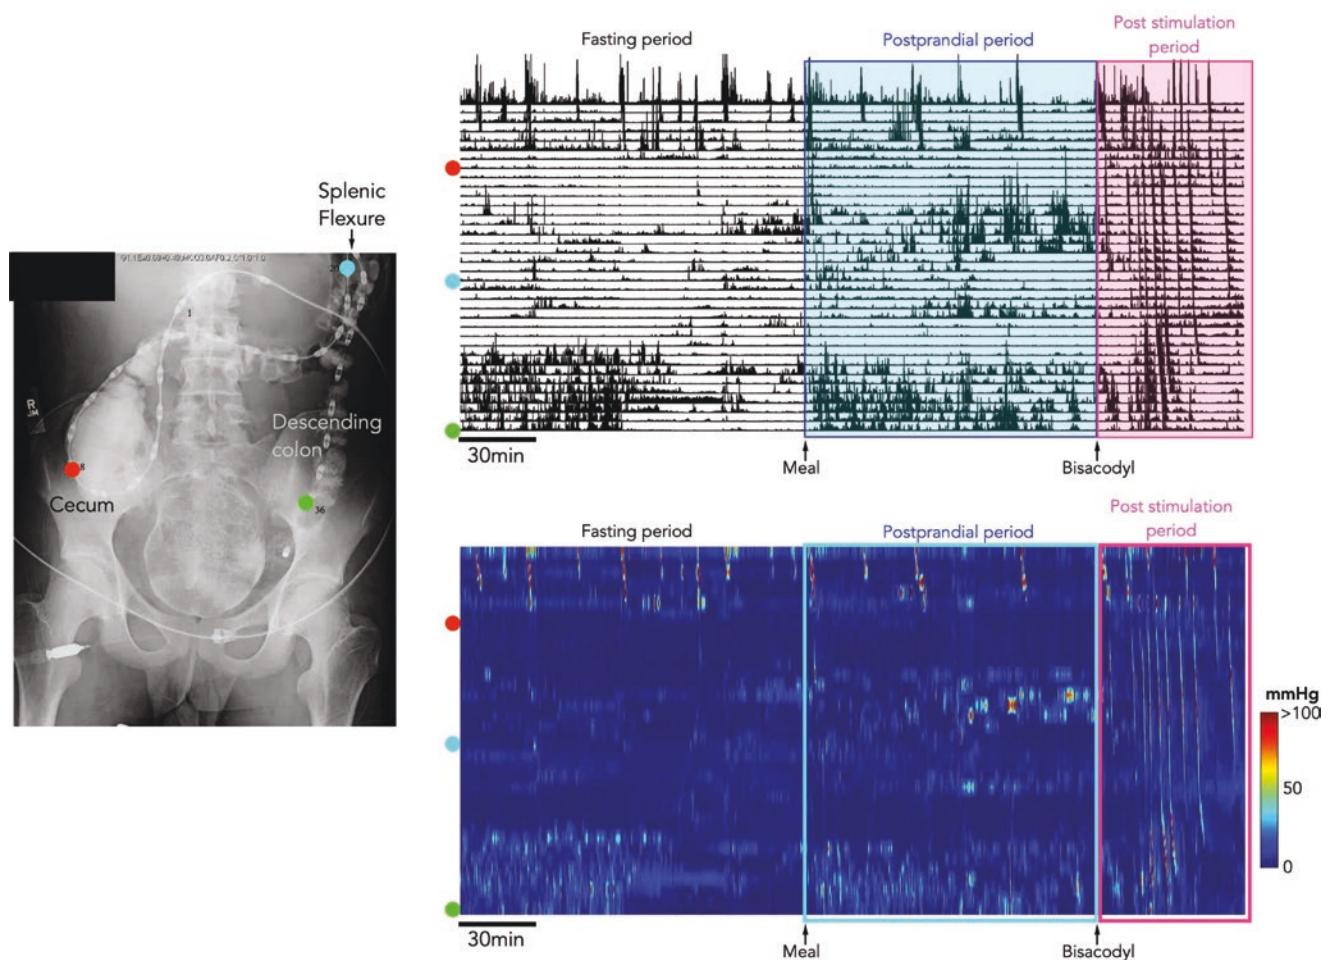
A 5.5-h-long colonic manometry study with fasting, postprandial, and post-stimulant motility tracing. The X-ray shows the catheter placement through a cecostomy, with the tip located in the sigmoid
